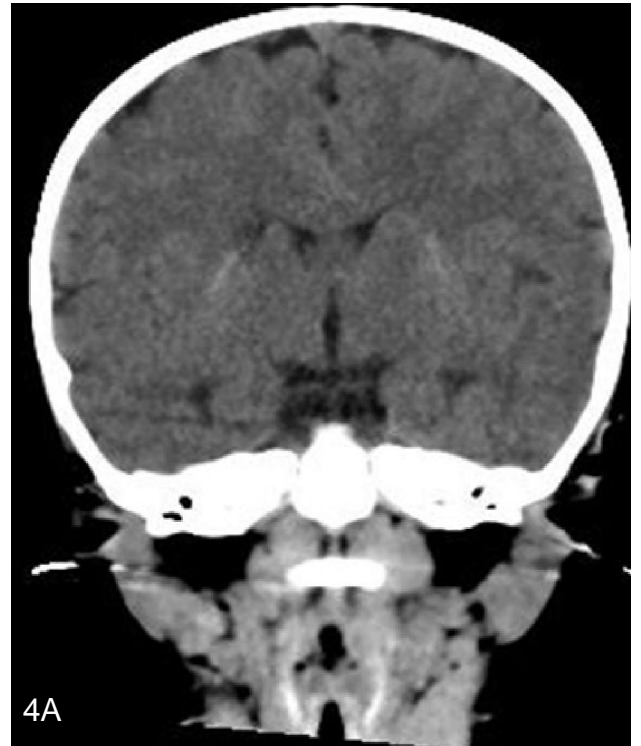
CT: Coronal and Sagittal reformatted images show linear distribution of calcification along course of lenticulostriate arteries.
